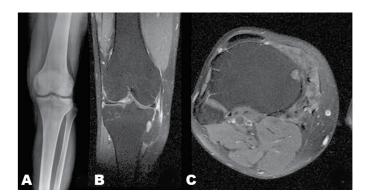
(A) X-ray and (B,C) Magnetic resonance imaging (MRI) scan of the mass. Anteroposterior diameter 54 mm, craniocaudal length 48 mm, mediolateral diameter: 12 mm.
